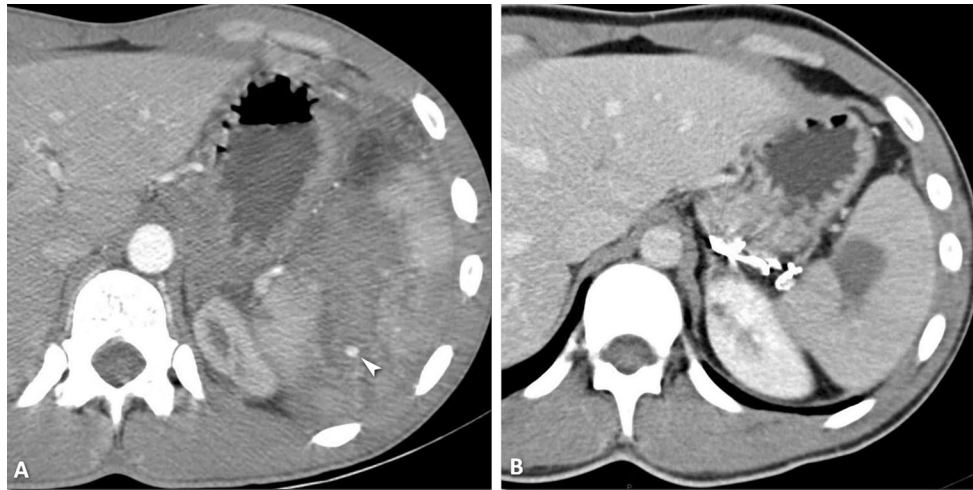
A post-traumatic splenic lesion grade IV treated with SAE. A CT at the admission show a laceration extended to hilar region with a major devascularization and a contrast blush (arrowhead). The
